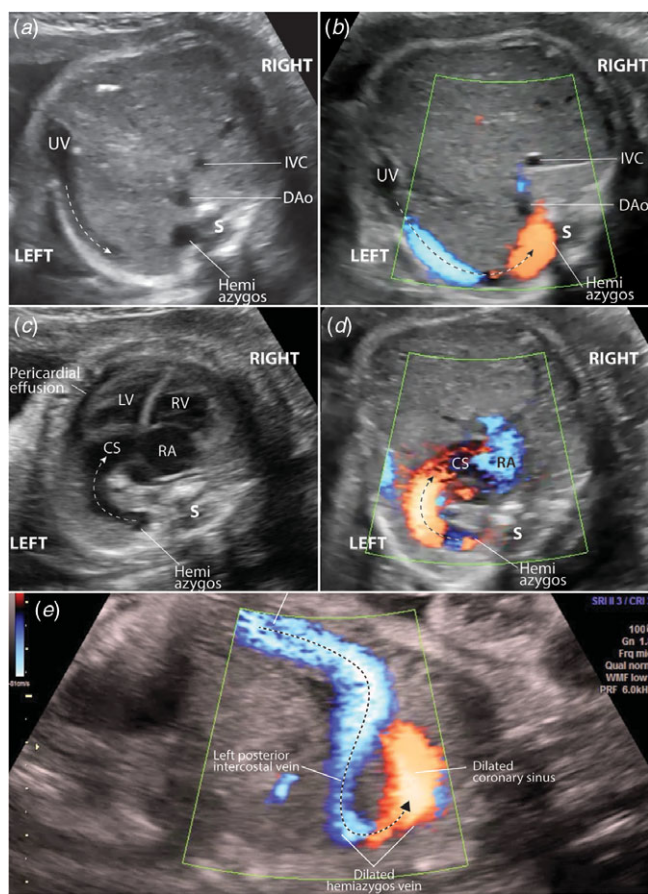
Foetal echocardiogram. (a) Transverse view of the foetal abdomen and (b) at the same level with colour Doppler showing the umbilical venous pathway into a left intercostal vein (broken arrows), and the dilated hemiazygos vein segment. (c) Transverse view at the level of the four-chamber view showing an arch (broken arrow) connecting the dilated hemiazygos vein to the very dilated CS. Note also the cardiomegaly and the cardiac apex pointing towards the right. (d) Colour Doppler of the flow from the dilated hemiazygos vein to the very dilated CS. (e) Sagittal view of the foetal abdomen and chest showing the unrestricted flow through the unusual pathway between the umbilical vein and the dilated coronary sinus (broken arrow). Note the dilated left posterior intercostal vein and hemiazygos vein segment. DAo=descending aorta; IVC=inferior vena cava; LV=left ventricle; RA=right atrium; RV=right ventricle; S=spine; UV=umbilical vein.
